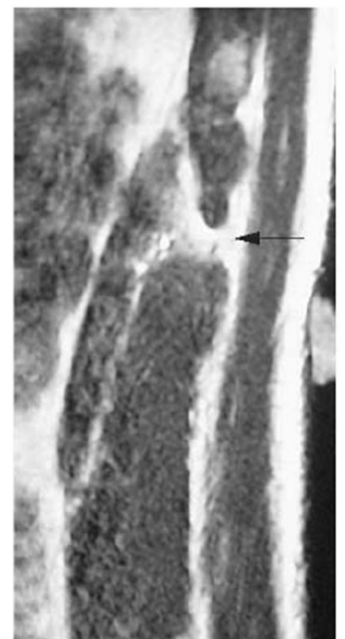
Magnetic resonance image of internal oblique full thickness tear (arrow). Note external marker at point of maximum tenderness.
